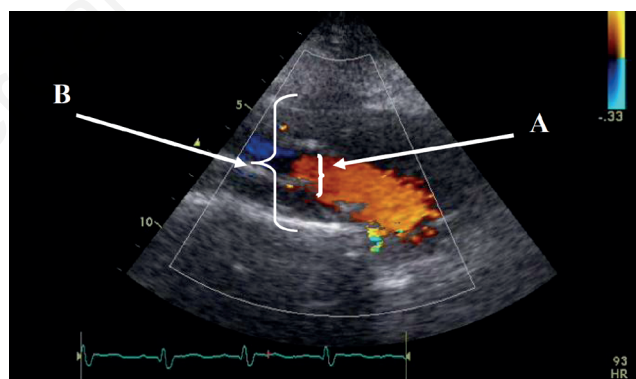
Echo-color Doppler image, B mode, long axis of true lumen (A, visible color flow) and false lumen (B, no flow).
